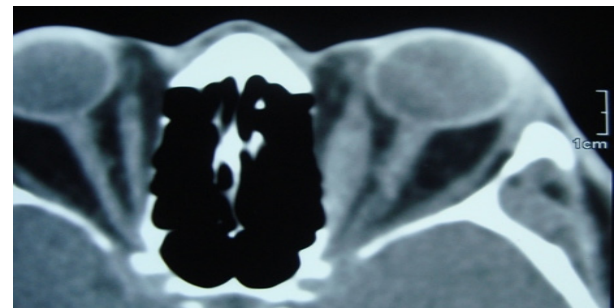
Axial sections of CT scan shows enlarged left medial rectus muscles with sparing of the muscle tendon.
